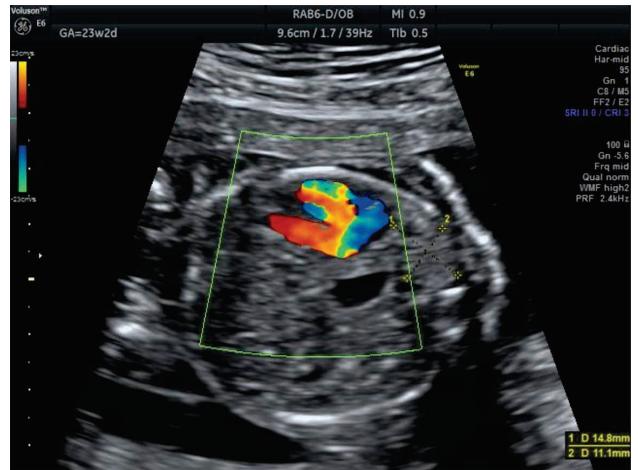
Ultrasound Doppler color image of the thorax containing the herniated stomach
